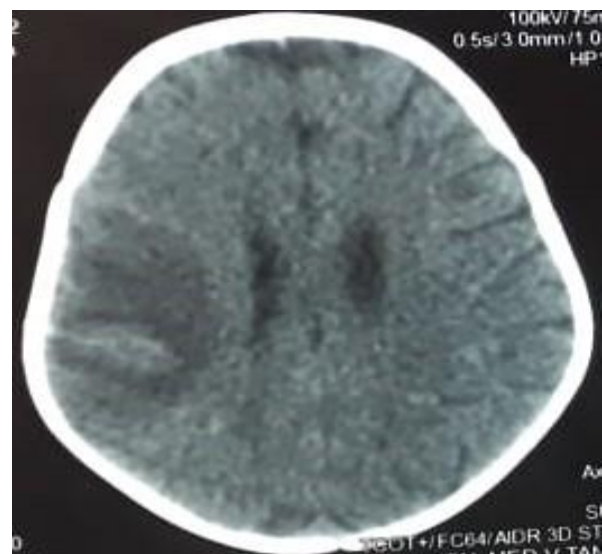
The brain CT objectified right ischemic temporo-parietal
